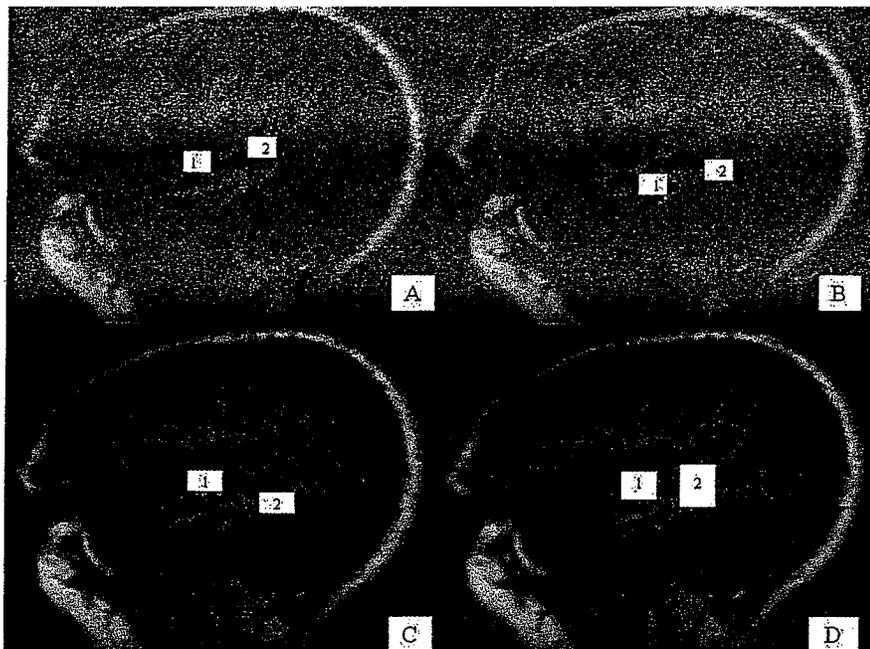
Reconstruction of the two distinct language areas identified by electrocortical language mapping over the left temporal lobe on a standard sagittal T2-weighted MR template. (A) Both located in the superior temporal gyrus. B) Both located in the middle temporal gyrus. (C) One located in the superior temporal gyrus and the other in the middle temporal gyrus. (D) One located in the superior temporal gyrus and the other intermixed between the superior temporal and middle temporal gyrus.
